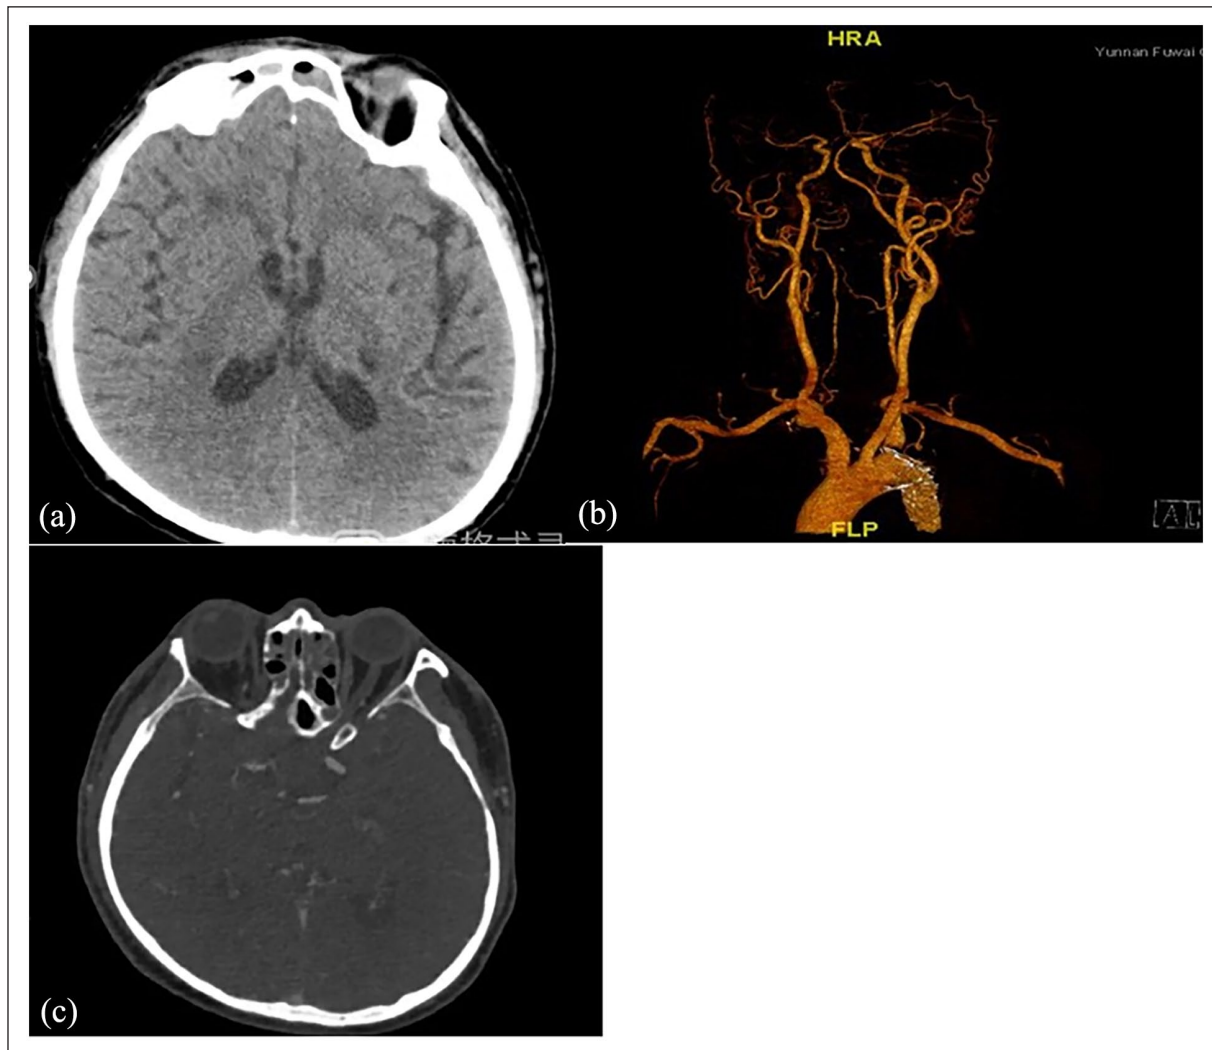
Presents a review of head CT (a) and computed tomography angiography (b and c).
